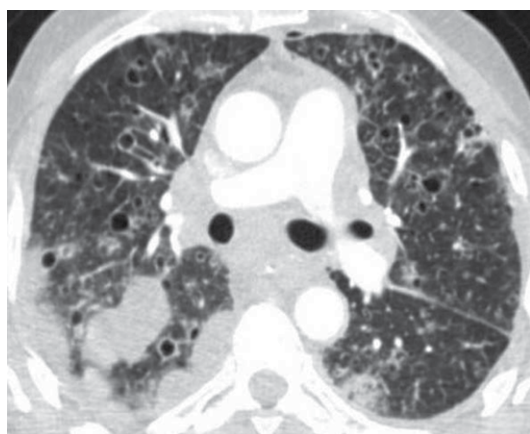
Axial reconstruction of a CT scan of a 66-year-old male patient with laryngeal squamous neoplasia. The scan demonstrates several cavitated nodules with a thick wall and cysts associated with loculated pleural effusion, also etiologically secondary to neoplasia.
